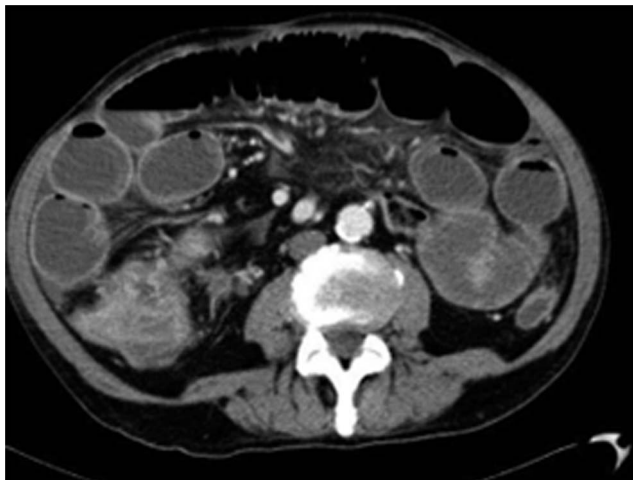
Computed tomography abdomen showing small bowel dilations concerning small bowel obstruction.
